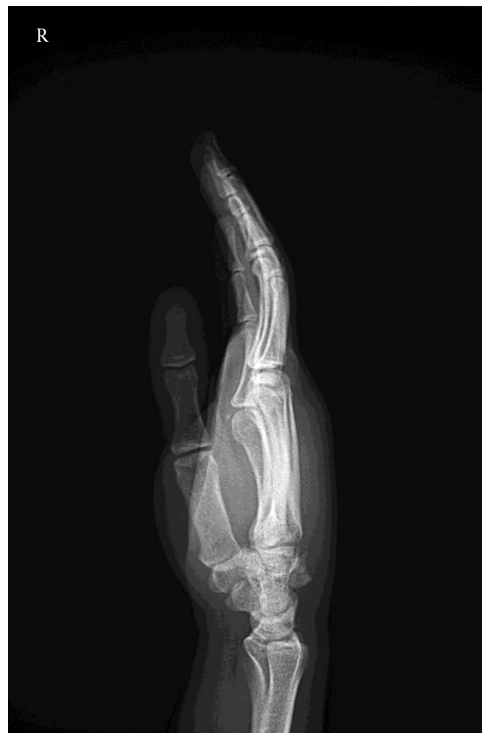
Lateral Radiograph of the Wrist Shows the Avulsion
